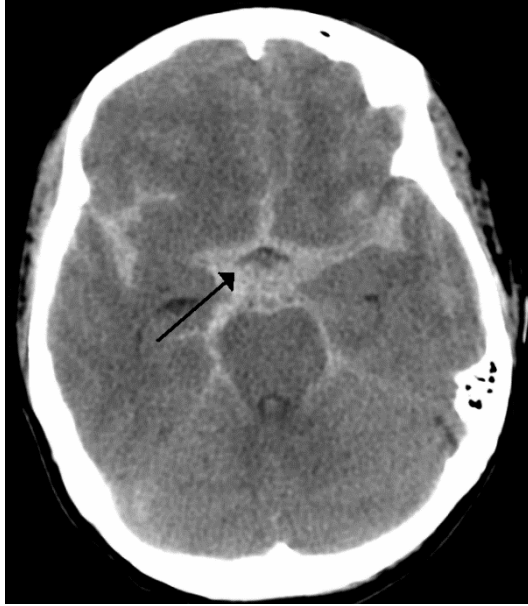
axial CT of subarachnoid hemorrhage
